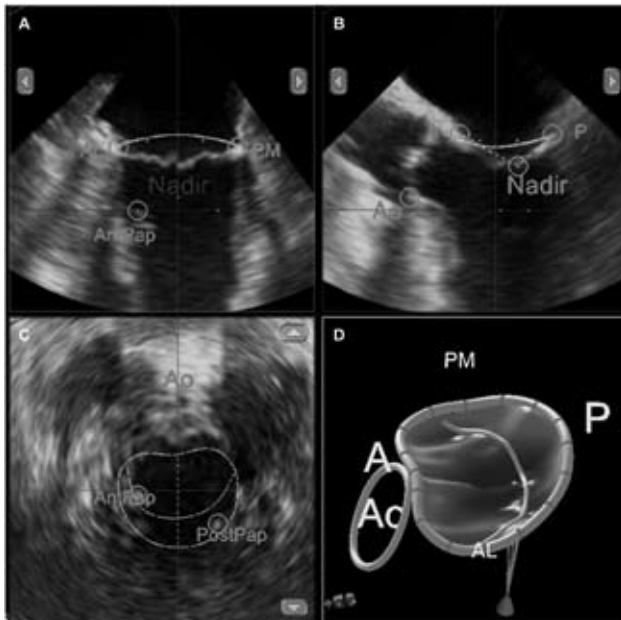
Using 3-dimensional transesophageal echocardiogram, Mitral Valve Quantification (MVQ) software generates a model of the mitral valve (panel D) by identifying manually placed reference points in the 2 chamber (panel A), 3 chamber (panel B) and short axis (panel C) multiplanar views. A: anterior; AL: anterolateral; P: posterior; PM: posteromedial; Ao: aorta; AntPap: anterolateral papillary muscle; PostPap: posteromedial papillary muscle.
